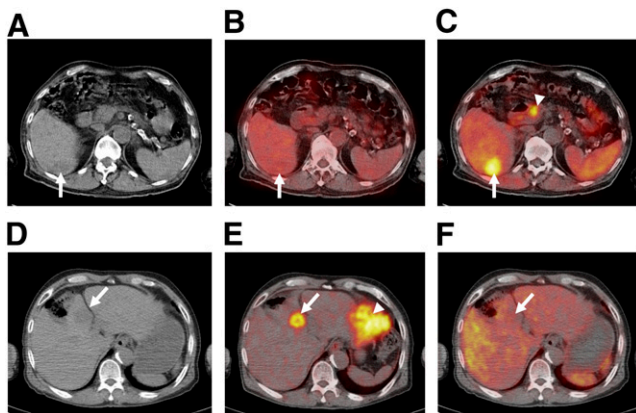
(A–C) Transaxial PET/CT images of 71-y-old man in whom HCC of Edmondson and Steiner's grade 1 was diagnosed. Unenhanced CT image shows hypoattenuating lesion in right lobe (arrow) (A), ^{18}F -FDG PET/CT image shows no focal ^{18}F -FDG accumulation in tumor (arrow) (B), and ^{11}C -acetate PET/CT image shows focally increased uptake of ^{11}C -acetate in tumor (arrow) and physiologic ^{11}C -acetate uptake in pancreas (arrowhead) (C). (D–F) Transaxial PET/CT images of 65-y-old man with HCC of Edmondson and Steiner's grade 3. Unenhanced CT image shows hypoattenuating lesion (arrow) (D), ^{18}F -FDG PET/CT image shows focal ^{18}F -FDG accumulation in tumor (arrow) and physiologic FDG uptake in myocardium (arrowhead) (E), and ^{11}C -acetate PET/CT image shows less intense accumulation in tumor (arrow) than in surrounding hepatic region (F).
